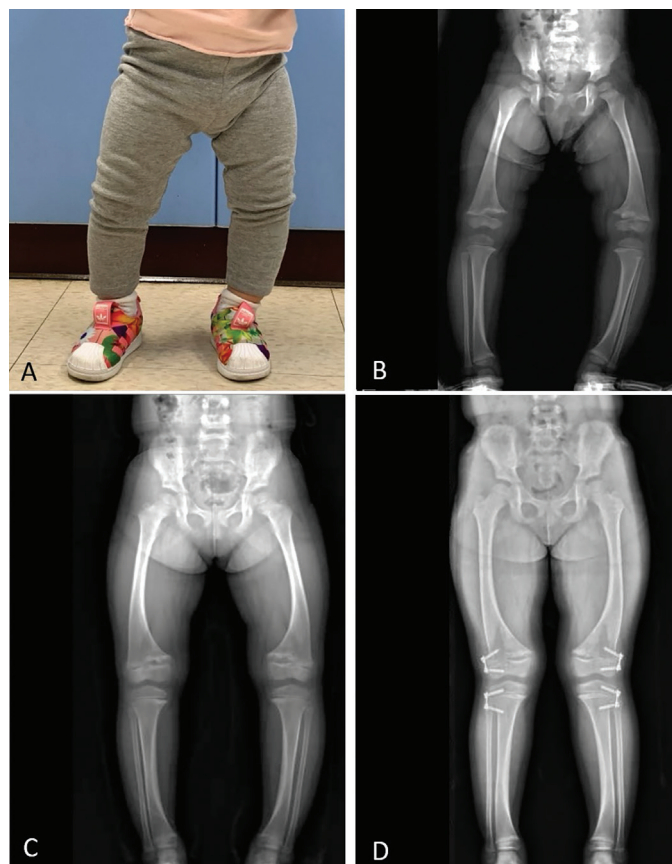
A) Bowlegs at diagnosis, B) X-ray of lower extremities at diagnosis, C) X-ray of lower extremities before guided growth, D) X-ray of lower extremities after guided growth and treatment of phosphate and calcitriol
